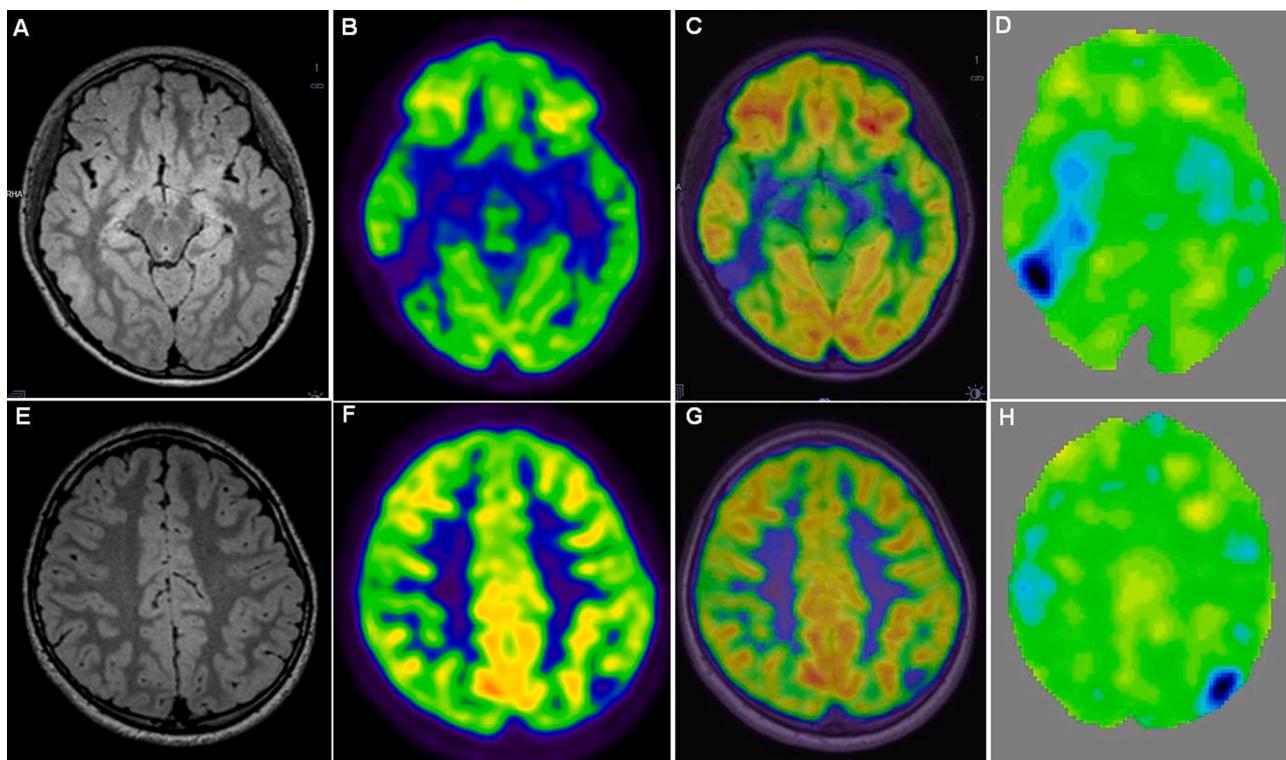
Hybrid PET/MRI increase in viewer confidence of multi-centric subtle epileptic lesions.
